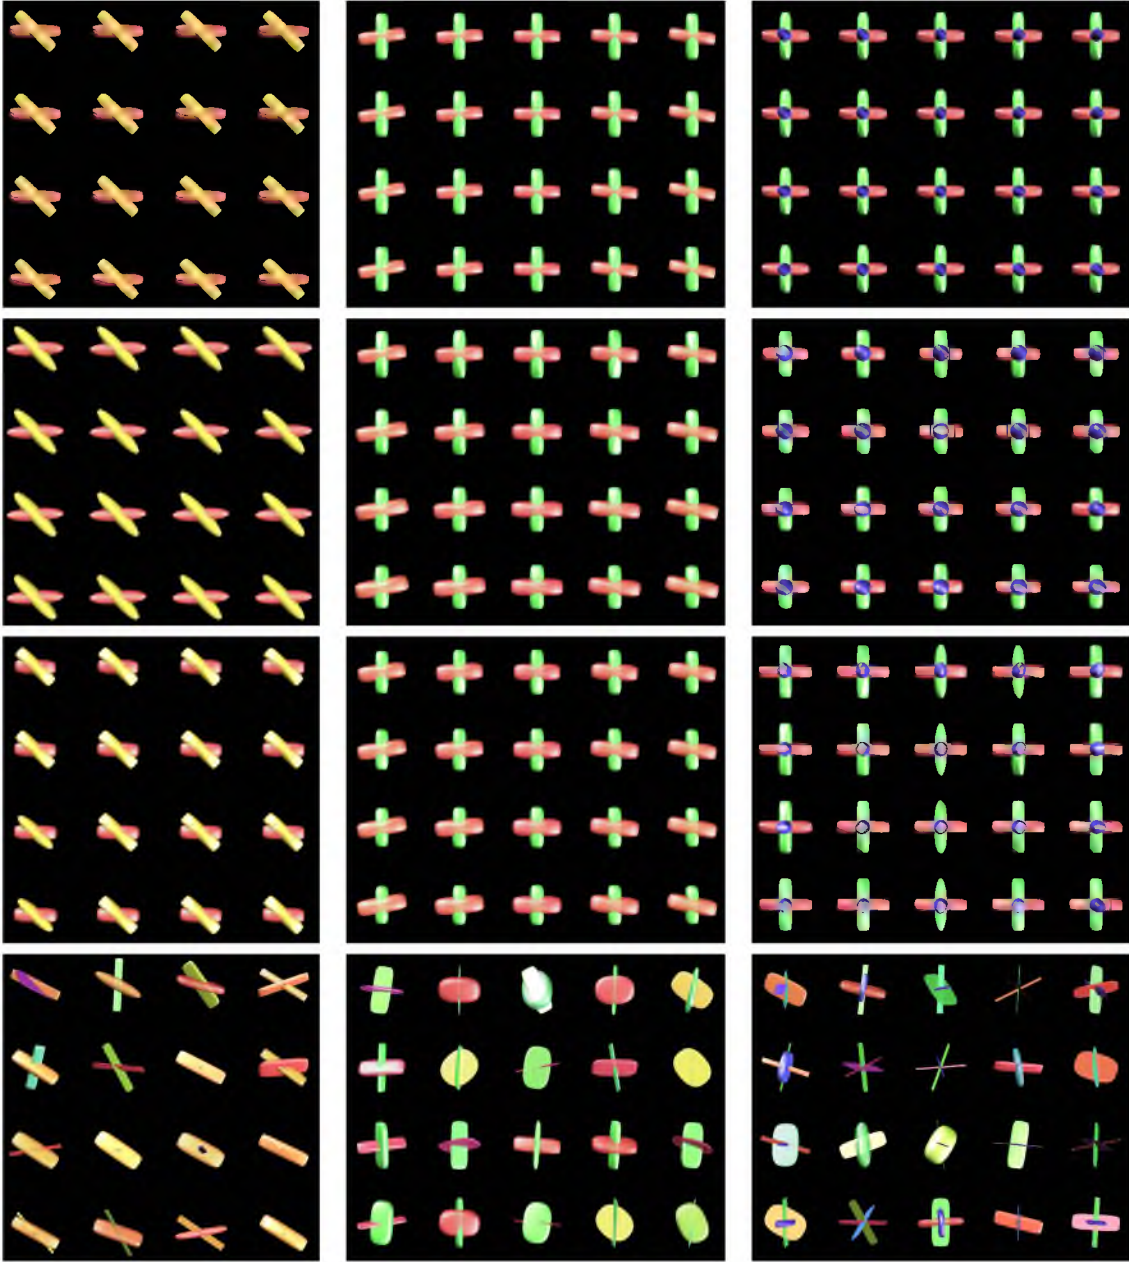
Estimated tensors of the crossing region for the three crossing datasets: first column is for the 45° crossing, second column is for the curved tract crossing, and the third column is for the three orthogonal tracts crossing. First row: our estimated tensors from noiseless 12-direction DWI. Second row: our estimated tensors from noisy 64-direction DWI. Third row: our estimated tensors from noisy 12-direction DWI. Fourth row: estimated tensors from Camino using noisy 64-direction DWI.
